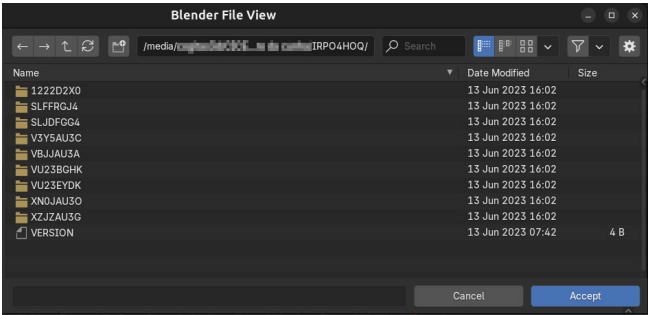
Selection of the computed tomography root directory.
